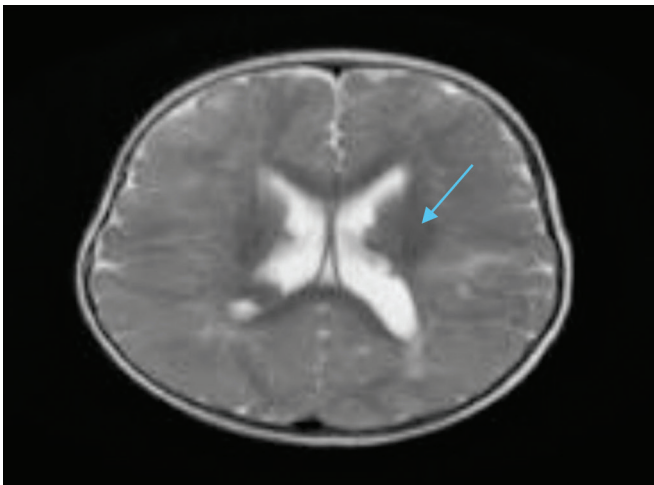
MRI brain showing bilateral T2 hypotense signal intensity lesion in periventricular region
